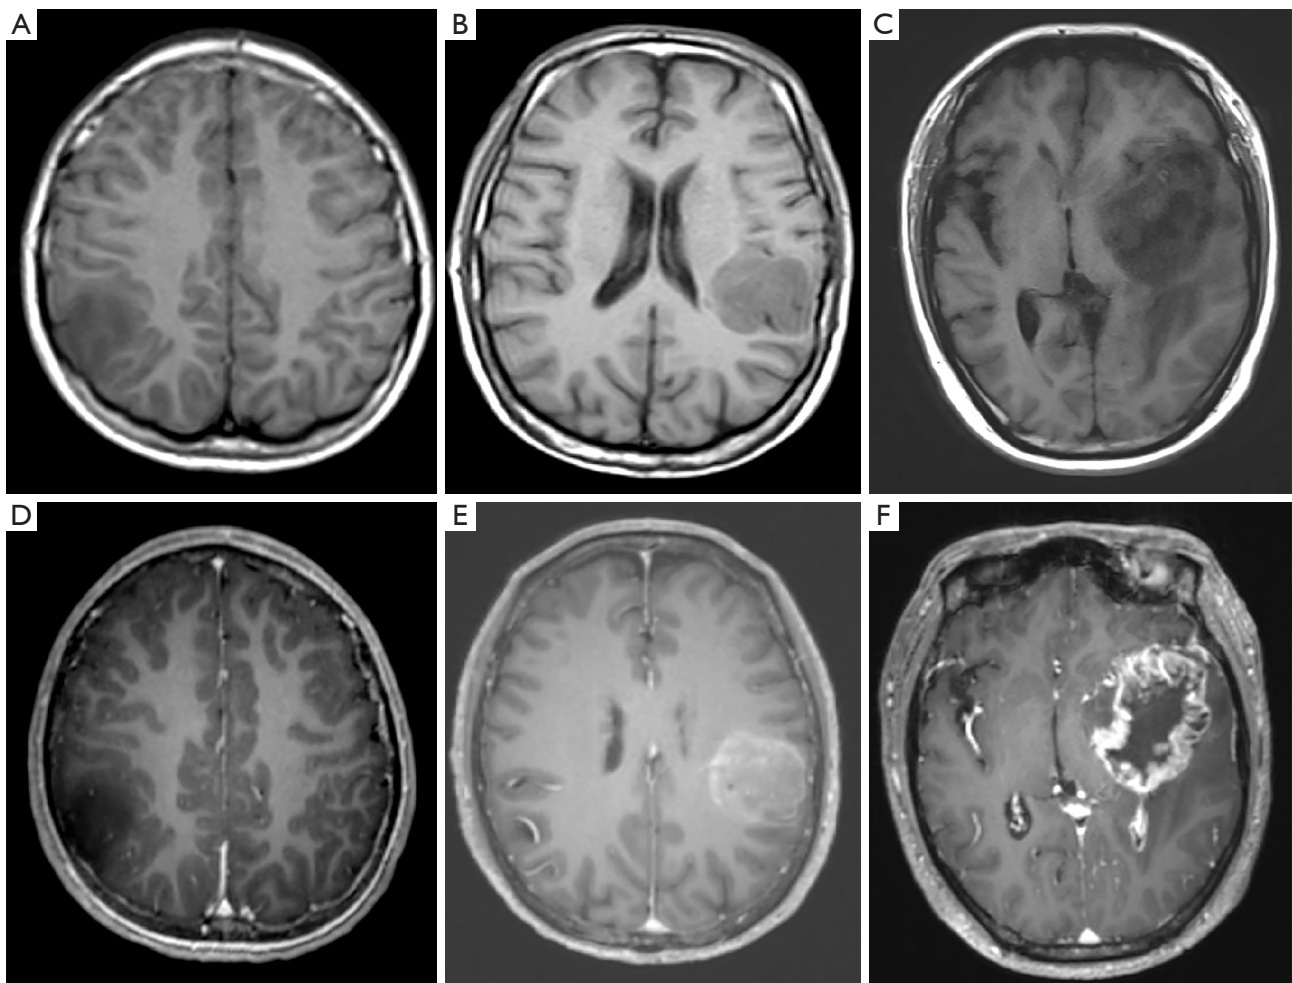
Examples of magnetic resonance images with different degrees of enhancement of Gb. (A-C) T1WI. (D-F) Contrast-enhanced T1WI. (A,D) No enhancement. (B,E) Mild or minimal enhancement. (C,F) Marked or avid enhancement. Gb, glioblastoma; T1WI, T1-weighted imaging.
